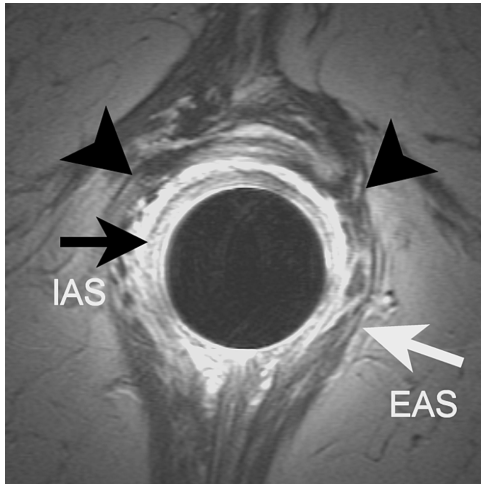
Transverse endoanal T2-weighted fast spin-echo (2500/70) MR image showing scar tissue (arrow heads) at the anterior EAS at the distal anal canal in a 56-year-old woman with a complicated vaginal delivery, hysterectomy and Lord-procedure in the past. This finding was confirmed at anal sphincter repair revealing an anterior EAS defect. IAS=lower edge internal anal sphincter, EAS= external anal sphincter
